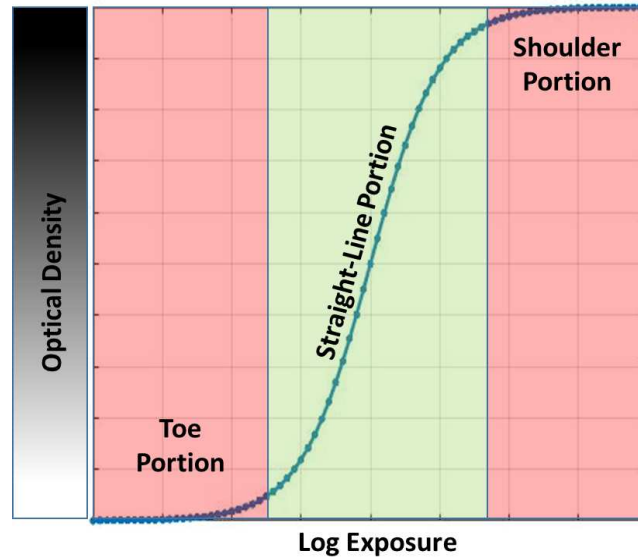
Characteristic response of an x-ray film (H&D curve).
